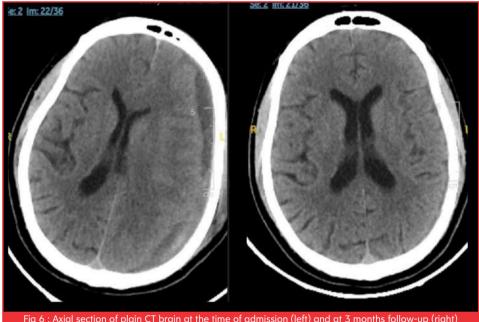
Axial section of plain CT brain at the time of admission (left) and at 3 months follow-up (right) showing complete resolution of the cSDH
